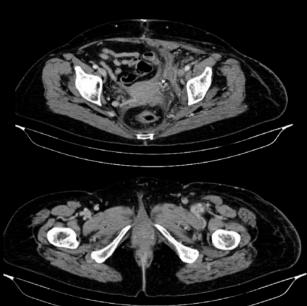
CT scan 30 days from discharge: recanalization of the left common femoral vein thrombosis and a reduction of the external iliac vein ipsilateral with almost complete resolution of edema of the limb.
